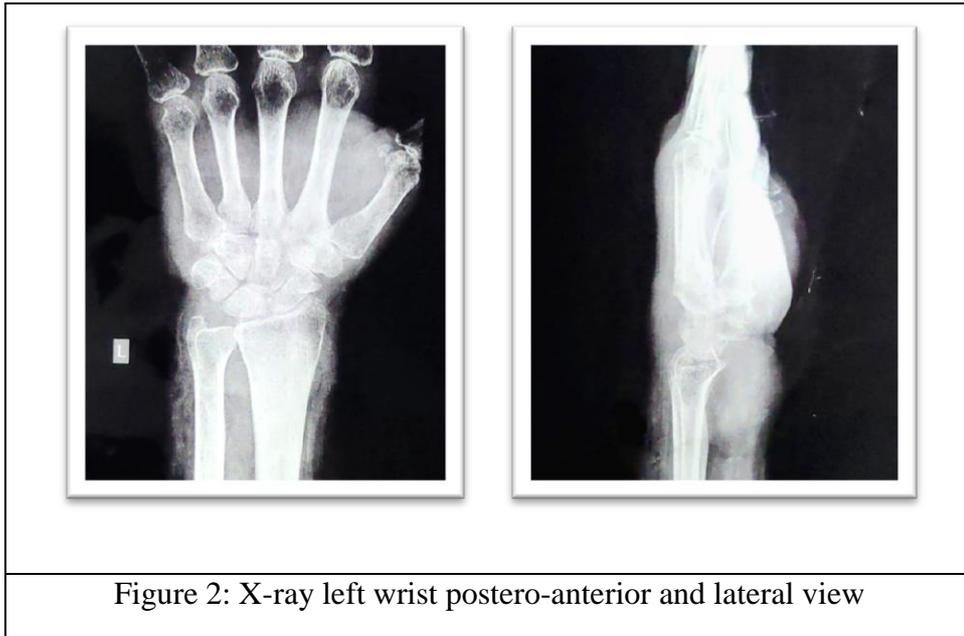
X-ray left wrist postero-anterior and lateral view
